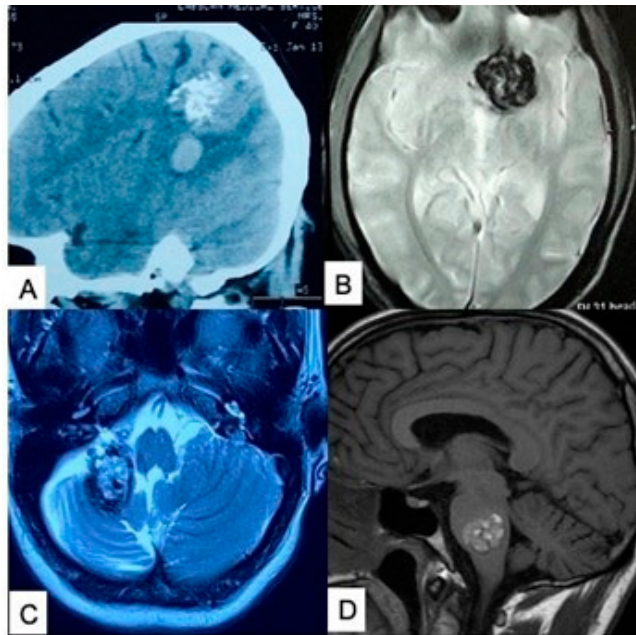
(A) CT scan showing a parietal cavernoma. (B) MRI showing a left basal frontal cavernoma. (C) MRI showing an rt cerebellar cavernoma. (D) MRI showing a pontine cavernoma. Source: Figure by authors.
